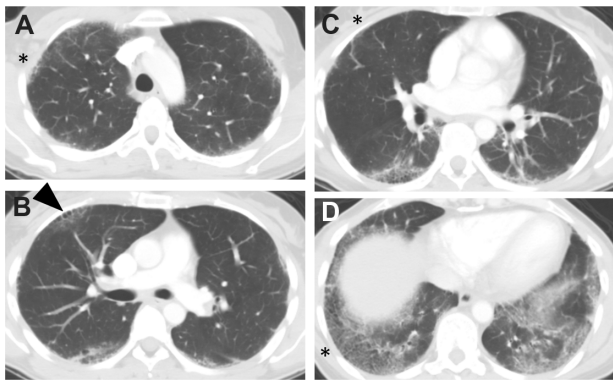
Representative chest tomographic (CT) images from the upper lobe (A), mid-lung region (B), and lower lobes (C and D) demonstrate bilateral, predominantly reticular, and peripheral opacities with associated traction bronchiectasis. The infiltrates are most prominent in the lung periphery and lower lung fields. Focal areas of early honeycombing may be seen in panel B (arrowhead).
